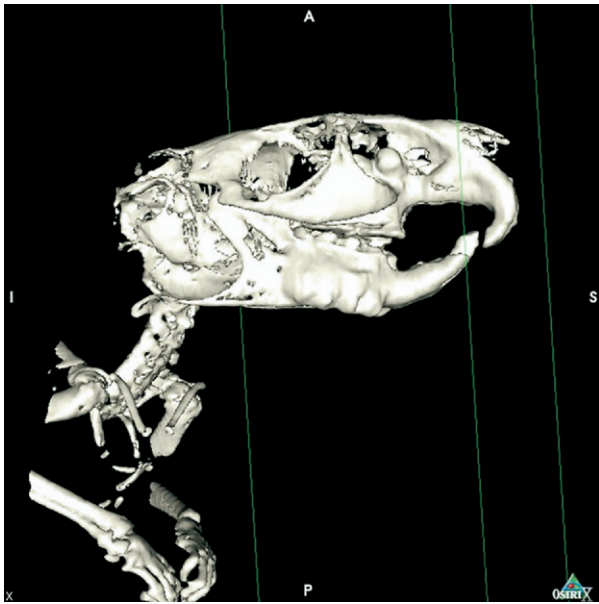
Computed tomography 3-dimensional surface reconstruction of the skull of a chinchilla with acquired dental disease of the cheek teeth. Apical deformities of the cheek teeth, typical of acquired dental disease in chinchillas, are visible. Severe apical elongation and deformity of right maxillary cheek tooth 1 and cheek tooth 2 are highlighted with this imaging technique. This can permit earlier diagnosis of acquired dental disease that may be contributing to vague clinical signs such as epiphora. Fracture of the right mandibular incisor is also present. Reprinted with permission from Capello V, Lennox A: *Clinical Radiology of Exotic Companion Mammals*, Blackwell Publishing, 2008.
